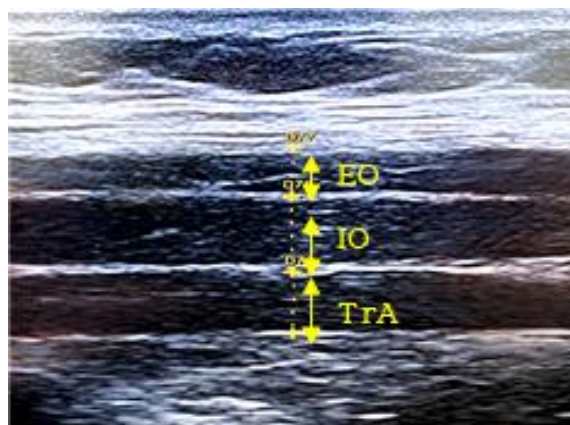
Ultrasound image of abdominal muscle thickness measurement
